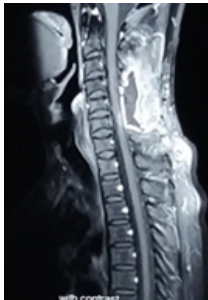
Post-operative – MRI Contrast Sagittal Image with no residual lesion
